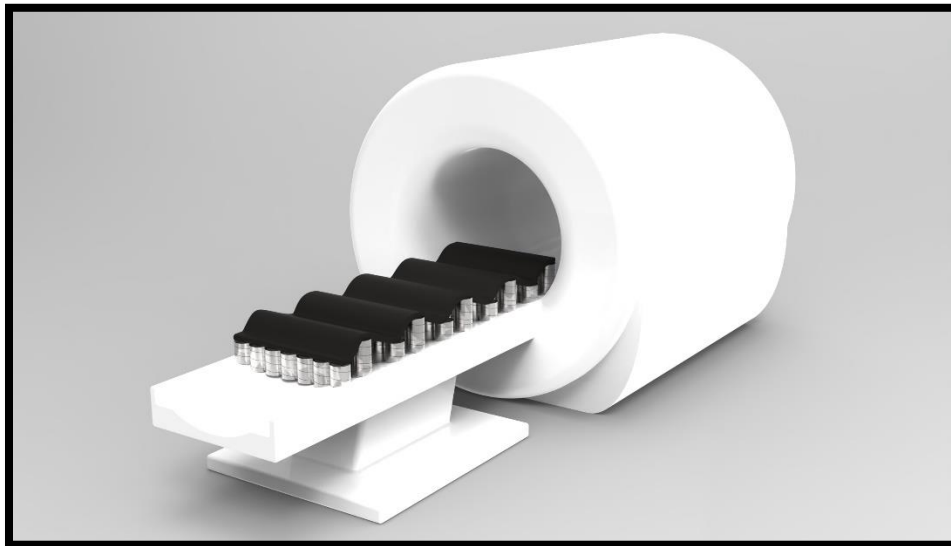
MRI render with actuator embedded in bed
